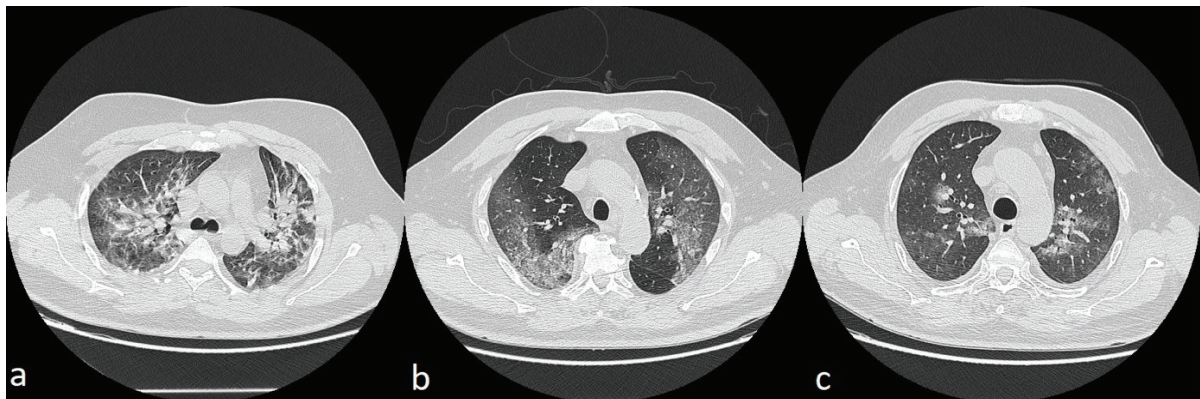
High-resolution CT (HRCT) presenting a percentage of pulmonary infiltration during SARS-COV 2 infection: (a) large involvement – more than 80% of infiltration, (b) 60% infiltration, (c) about 30% infiltration
